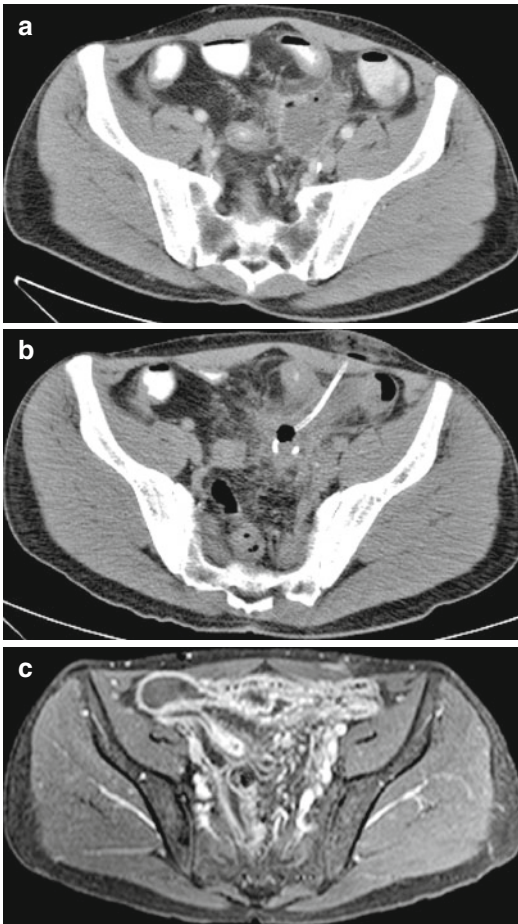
Sigmoid diverticulitis with 5-cm abscess formation (note air bubbles) (a). A 12-F drainage catheter was placed using a ventral transabdominal approach. Bowel loops are identified after oral contrast administration. The documentation after fluid evacuation showed significant size reduction (b). Follow-up MR imaging 3 weeks after drainage shows complete resolution (c)
